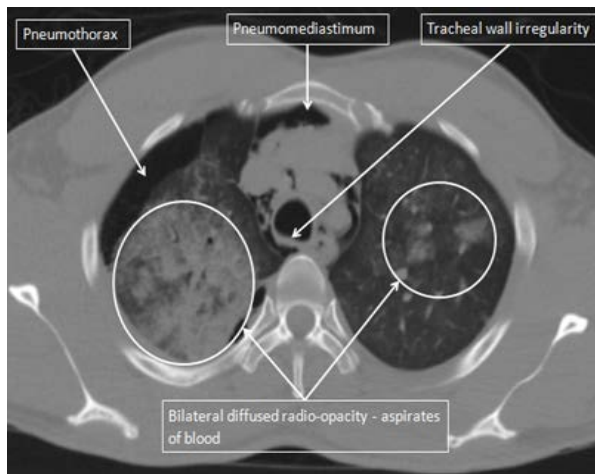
Chest CT scan demonstrating right pneumothorax, pneumomediastinum, bilateral pulmonary haemorrhage and an irregularity in the posterior wall of the tracheal
